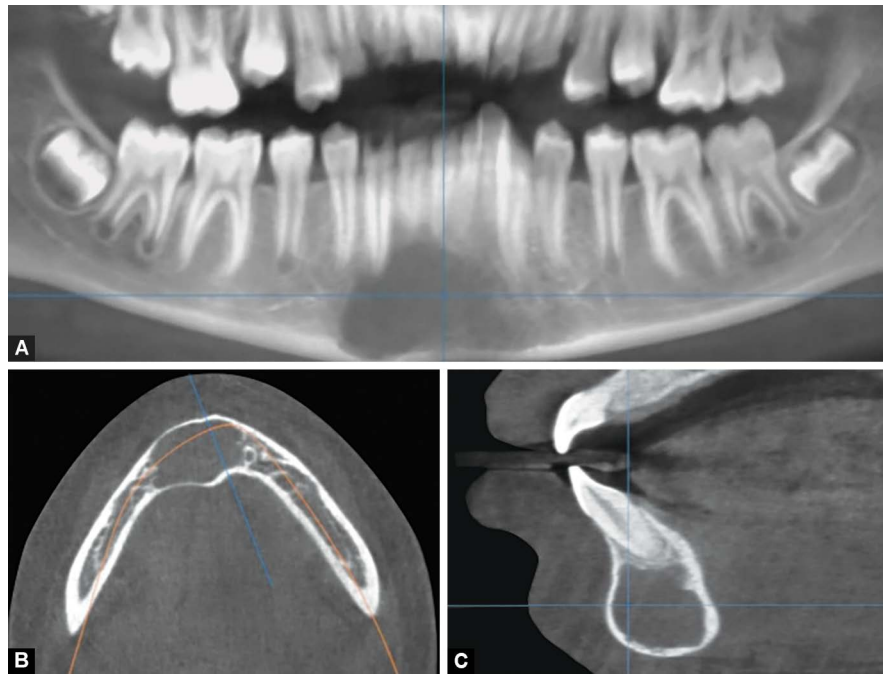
Orthopantomograph
